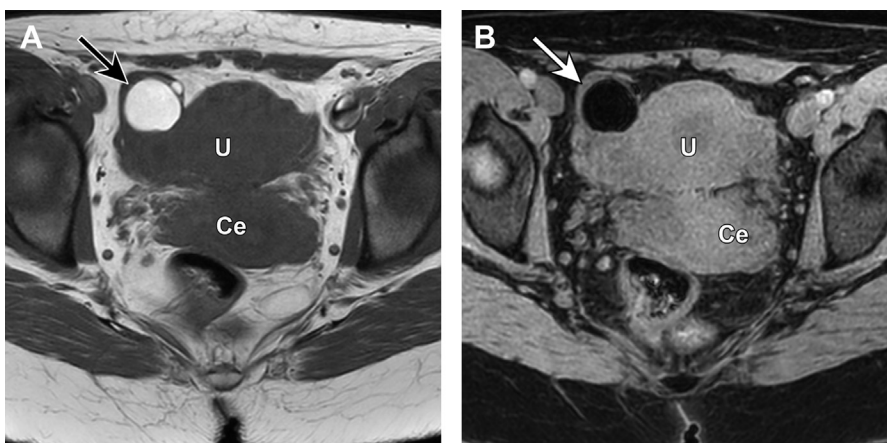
Mature cystic teratoma of the right ovary (arrow). Axial precontrast T1-weighted MR image (A) shows a unilocular lesion with homogenous hyperintense signal (*black arrow*). Axial T1-weighted image with fat saturation (B) shows loss of signal within the lesion indicating macroscopic fat, characteristic of a mature cystic teratoma (*white arrow*). No internal enhancement. U, uterus; Ce, cervix.
